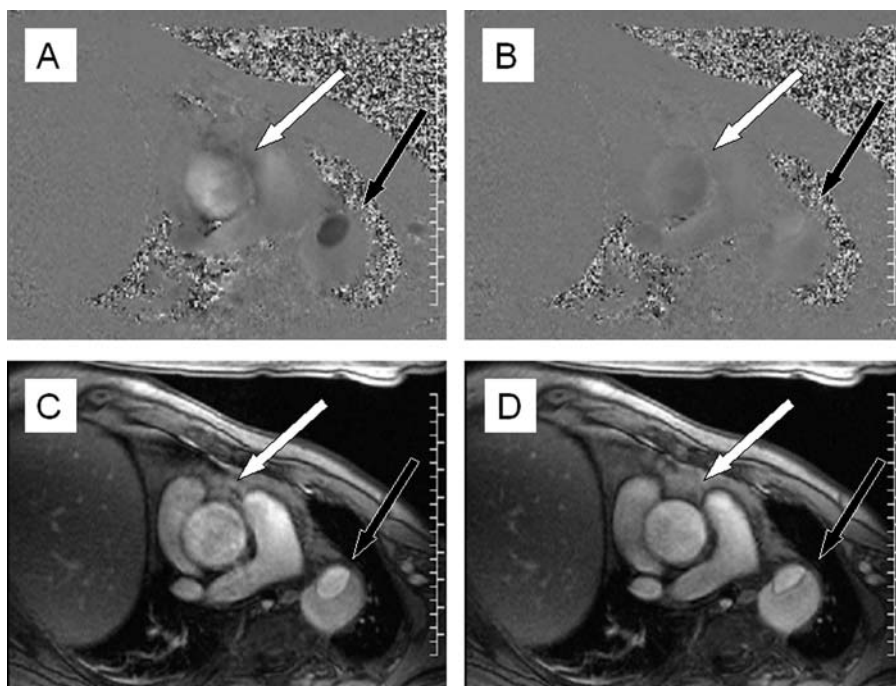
Phase contrast sequences in MRI in a patient with severe aortic regurgitation and a type B aortic dissection. Transverse plane. A: Phase contrast in systole. The ascending aorta shows high signal intensity with fast flow toward the head (white arrow). The true lumen in the descending aorta is dark, meaning fast flow in the opposite direction (black arrow). The false lumen of the descending aorta is encoded gray similar to the surrounding structures, indicating slow flow or no flow. B: Phase contrast in diastole. The ascending aorta is now slightly dark, indicating flow towards the left ventricle, caused by aortic regurgitation. C: The corresponding magnitude image to panel A, showing the anatomic structures at the same time. D corresponds to panel B.
